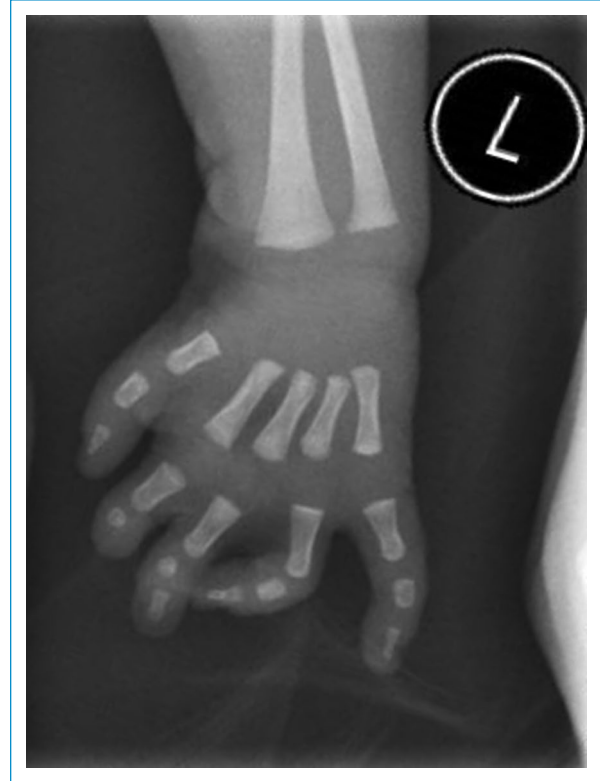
Left-hand x-ray showing hypoplasia of the middle phalanx and agenesis of the distal phalanx of the 2nd finger and hypoplasia of the middle phalanx of the 3rd finger.
